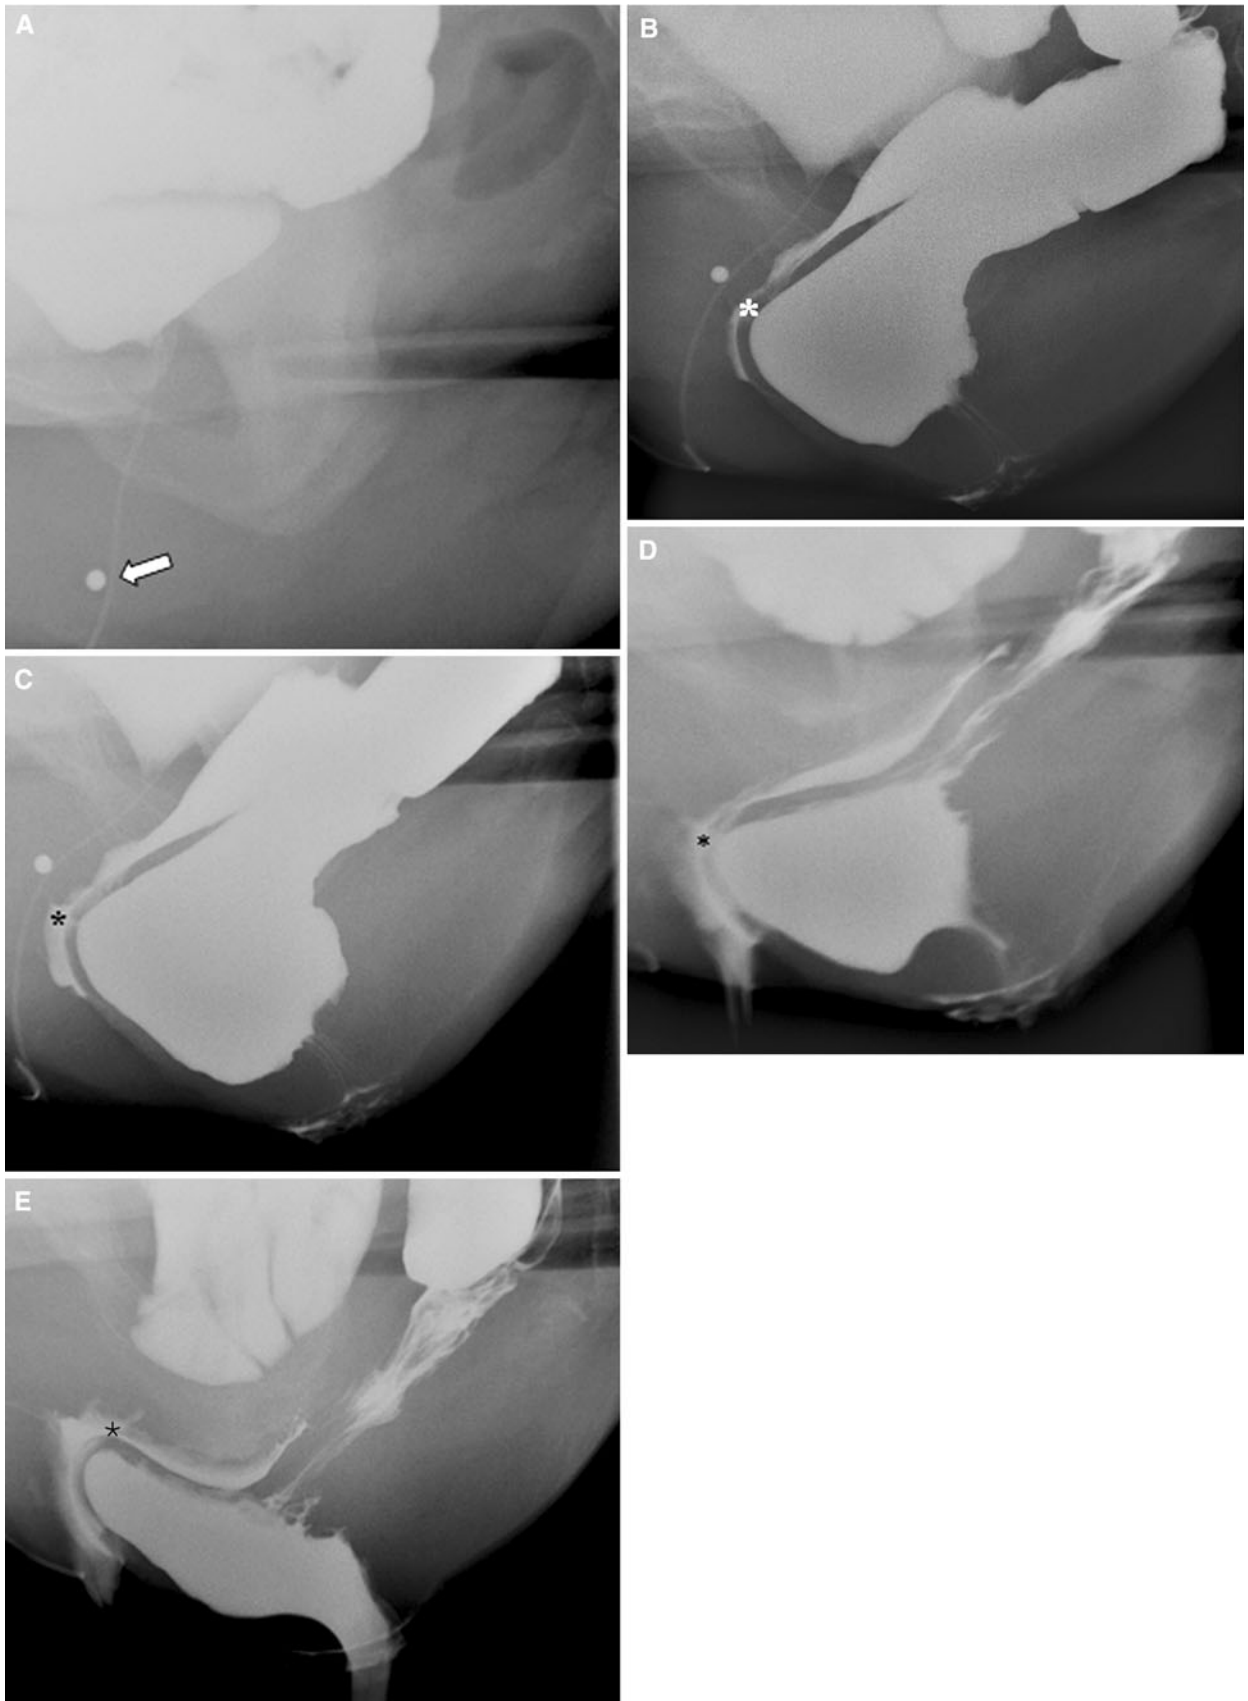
Determination of the level of the PH with DCP, the reference point for staging pelvic organ prolapse. Lateral radiograph obtained A with the patient in the fluoroscopic table with a marker (*arrow*) secured at the level of the urethral meatus following contrast administration into the urinary bladder. Anatomically in vivo, the hymen is at the same level as the urethral meatus which is immediately posterior to the vaginal fourchettes B at rest following placement of vaginal and rectal contrast, C during straining, D at rest following defecation, and E during marked straining following defecation. Level of vaginal fourchettes is marked by *asterisk*. The leading edge of the anterior rectocele is anterior to the level of the PH, a stage 2 ICS posterior vaginal wall prolapse
